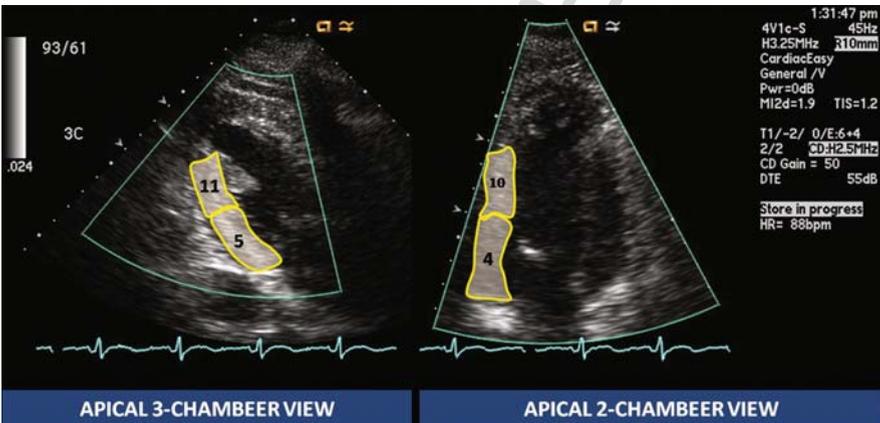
Transthoracic echocardiogram. Transthoracic echocardiography at the time of chest pain revealed hypokinesis of the basal and mid segments of the inferior and posterior (inferolateral) walls (segments 4, 5, 10, and 11). There were no other left ventricular wall motion abnormalities including the regions supplied by the distal LAD (segments 13–17) where in-stent restenosis had occurred
